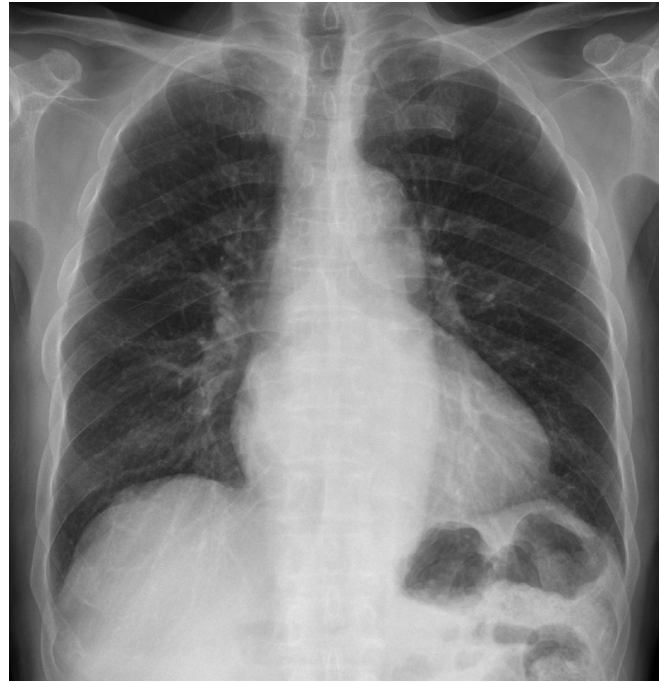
Images of chest X-ray
